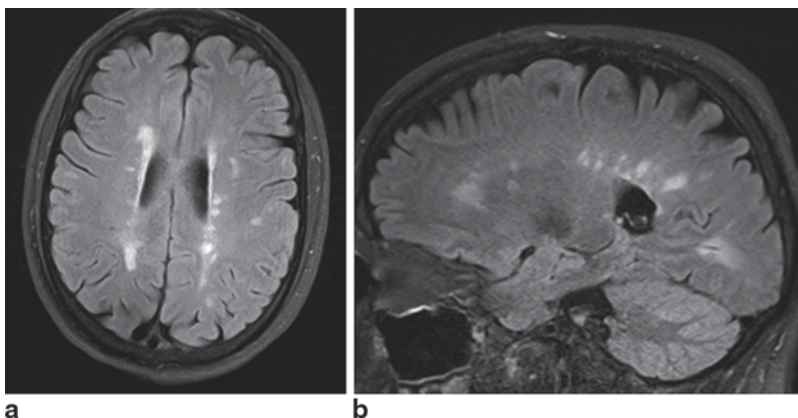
T2 FLAIR MRI scans in 35-year-old woman with MS showing a in axial view, bright lesions adjacent to the ventricles and b in sagittal view, bright lesions in corpus callosum (Courtesy of Blaine Hart, MD)
